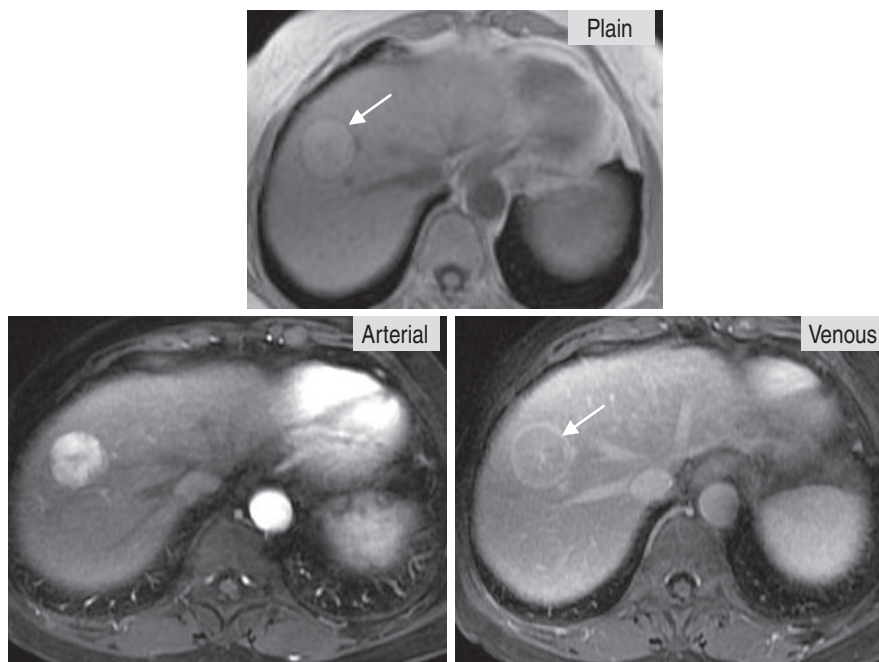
MRI with extracellular contrast agent shows arterial enhancement, and rapid venous washout, which is characteristic for HCC. Also note a thin capsule of HCC (arrow).
